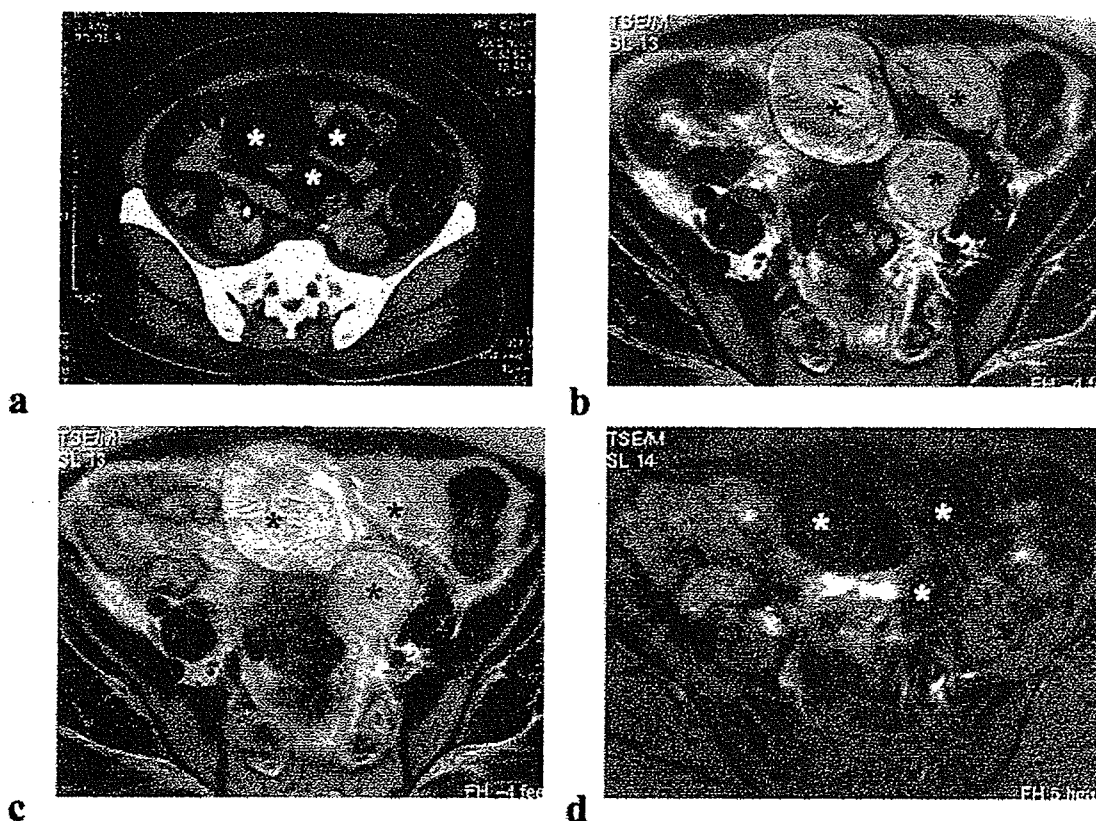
Computed tomography (CT) and magnetic resonance imaging (MRI) findings of liposarcoma. (a) White asterisk indicates one of the heterogeneous masses with fat density in the pelvic cavity detected by CT examination. (b) Black asterisk denotes well-defined masses with a high intensity by both T₁-weighted images of an MRI examination. (c) Black asterisk denotes well-defined masses with high intensity based on T₂-weighted images of an MRI examination. (d) White asterisk shows the masses with a low signal intensity based on T₁-weighted images with fat suppression.
